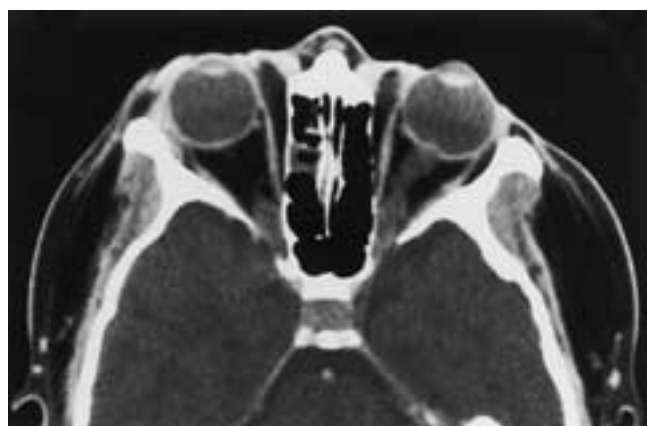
Optic papilledema. Axial CT scan shows bulging of the left optic disc in this patient with bilateral papilledema. There was bilateral optic disc enhancement on enhanced T1-weighted MR images.
